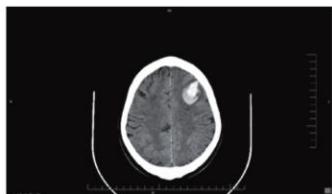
Computed tomography of brain showing second episode of left frontal bleed and right frontal encephalomalacia from the first episode.
